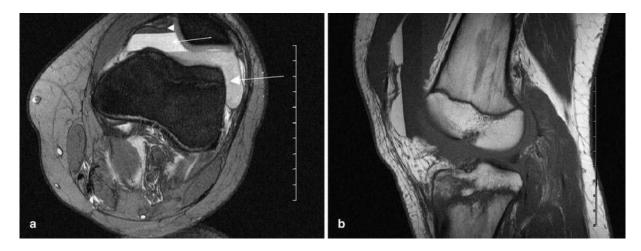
a Left knee, transverse section. Conventional MRI scanner (Siemens Sonata, 1.5 T). A MEDIC sequence (TR/TE/flip angle: 1380 ms/24 ms/25°). A double-fluid level is visible. Note the low signal intensity of the highest layer, which is comparable to surrounding fatty tissue (*arrowhead*). A high-intensity band follows and consists of serum (*small arrow*). Cellular parts of blood have sedimented and display an intermediate signal (*large arrow*). b Left knee, sagittal section. A MEDIC sequence. The same double-fluid level as in a can be seen. Note the clear distinction between the three layers
